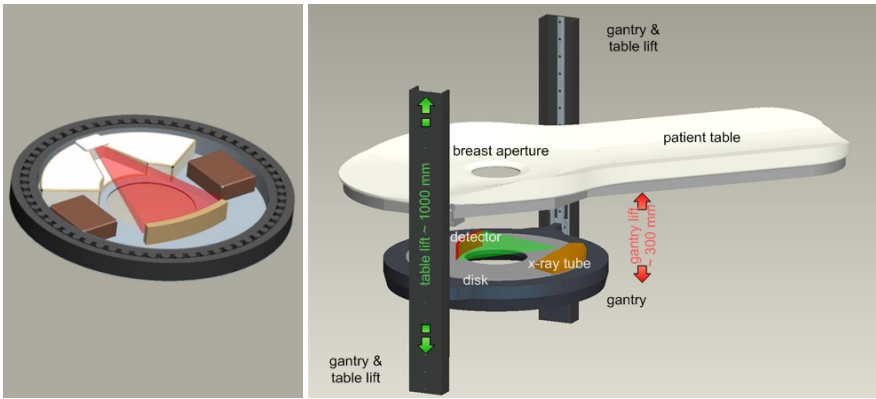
Proposed CT concept. a) Source-detector design similar to that of modern clinical CT. b) Novel patient-friendly scanner concept which also allows for biopsy taking.
